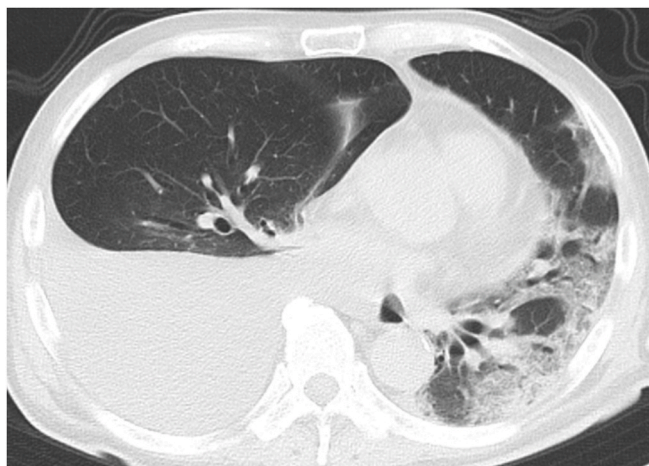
Computed tomography on the 9th day of hospitalization.
